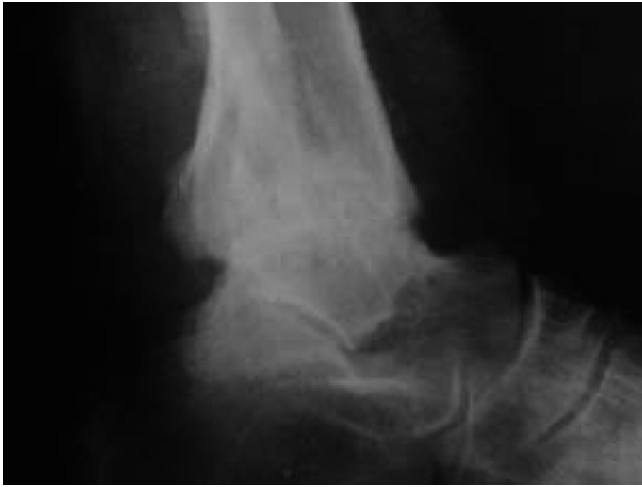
Lateral ankle weightbearing x-ray, 36 months post operative film.
